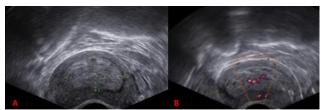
(A-B): Enlarged uterus with a thick, heterogeneous endometrium that was very vascularized by Doppler
